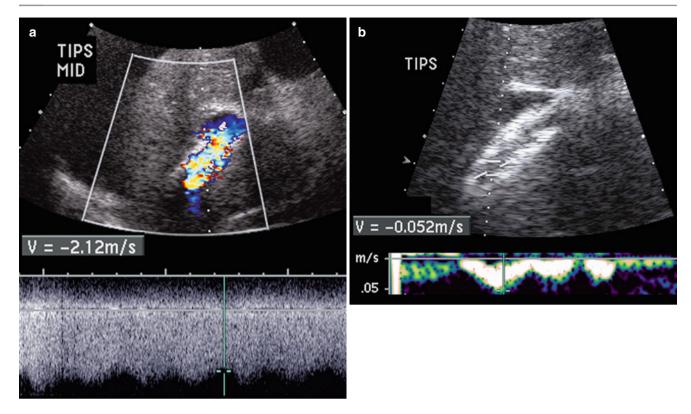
TIPS malfunction. (a) Color and spectral Doppler sonogram of TIPS demonstrating mildly elevated velocities of 212 cm/s, raising concern for malfunction. (b) Three months later, there is almost no flow in the TIPS with a peak velocity of only 5 cm/s
